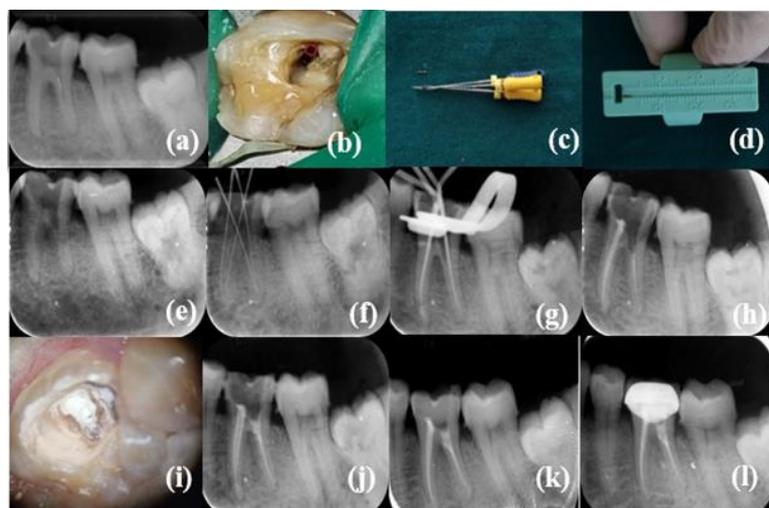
(a) 3.5 mm of the file separated in DB canal in the coronal third, (b) Coronal part of file under DOM, (c) Braiding technique for removal of separated instrument, (d) Length of retrieved instrument measured on endogauge, (e) Radiograph following retrieval, (f) Working length determination, (g) Mastercone verification, (h) Furcation perforation near the DB canal, (i) Furcation perforation repair with MTA under DOM, (j) Radiograph following furcation perforation repair with MTA, (k) 6 months follow-up, (l) PFM crown cementation
